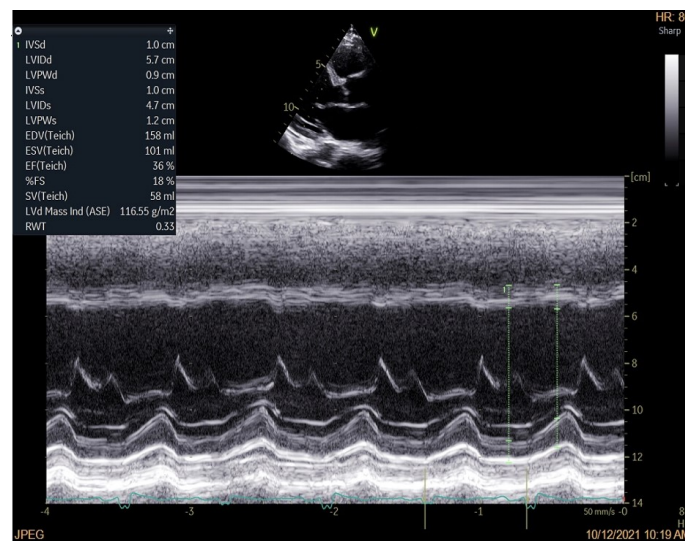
LV Study Echocardiography
